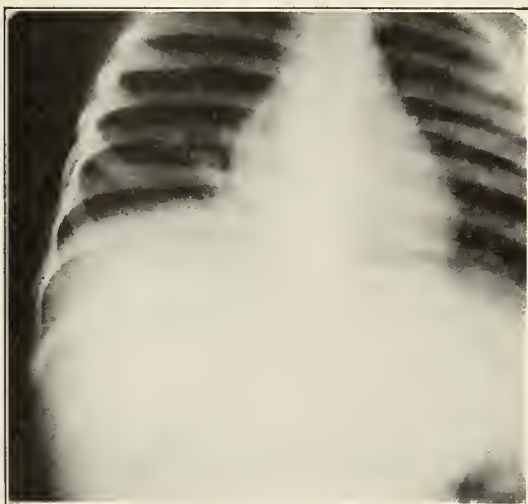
No lesions in lungs except increased height of right diaphragm. Above roentgenogram interpretations by Dr. Ira H. Lockwood.
